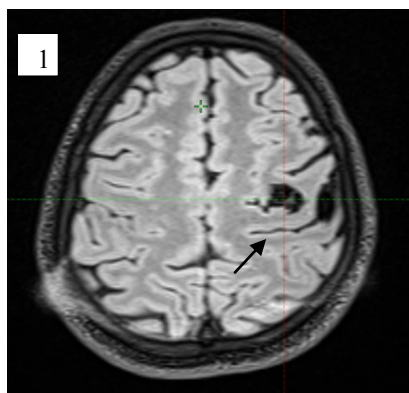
Pre treatment T1 MRI depicting AVM nidus.
